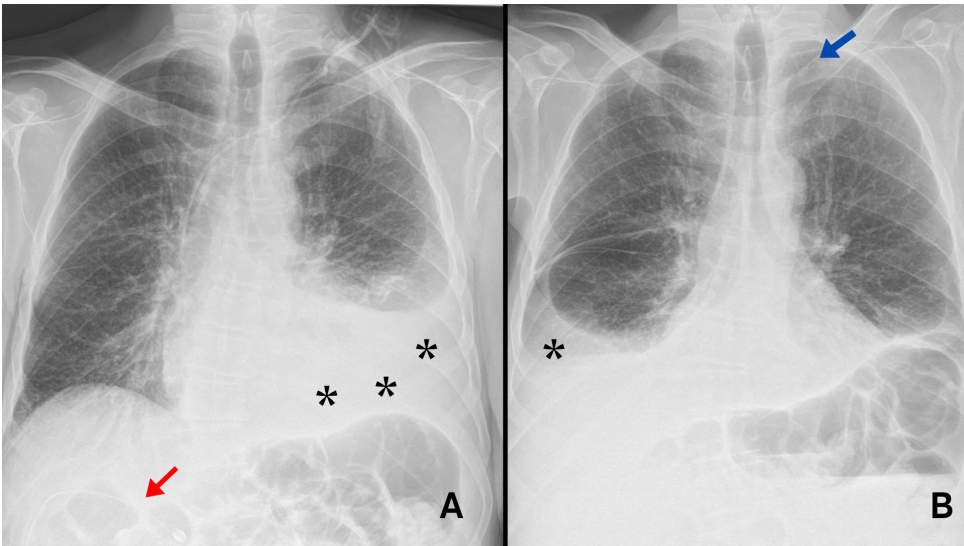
Chest X-ray imaging prior the procedure (A) and at six months follow-up (B).
